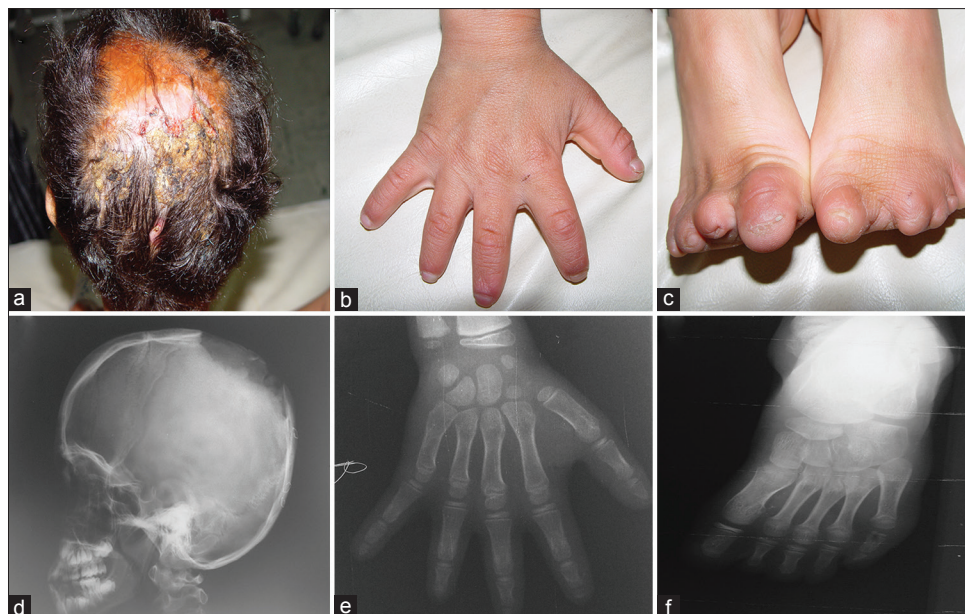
The patient presented with scalp defect (a) as well as upper (b) and lower limb (c) anomalies. Skull X-ray revealed bone defects (d). Upper (e) and lower limb (f) X-ray showed absent or short distal phalanges
